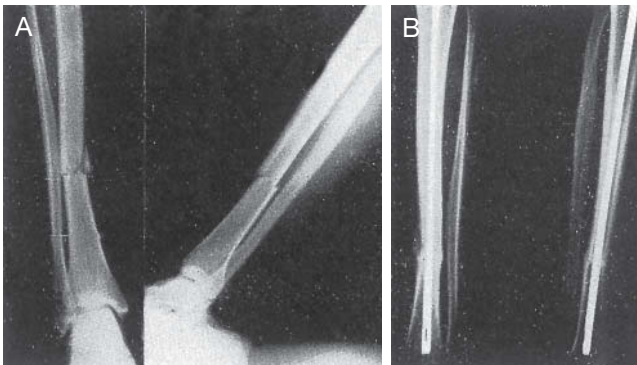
F.B.H. Transverse tibial fracture with an intact fibula. A: Preoperative x-rays (note slight angulation of fracture site). B: X-ray showing full bone healing at 2 months.
